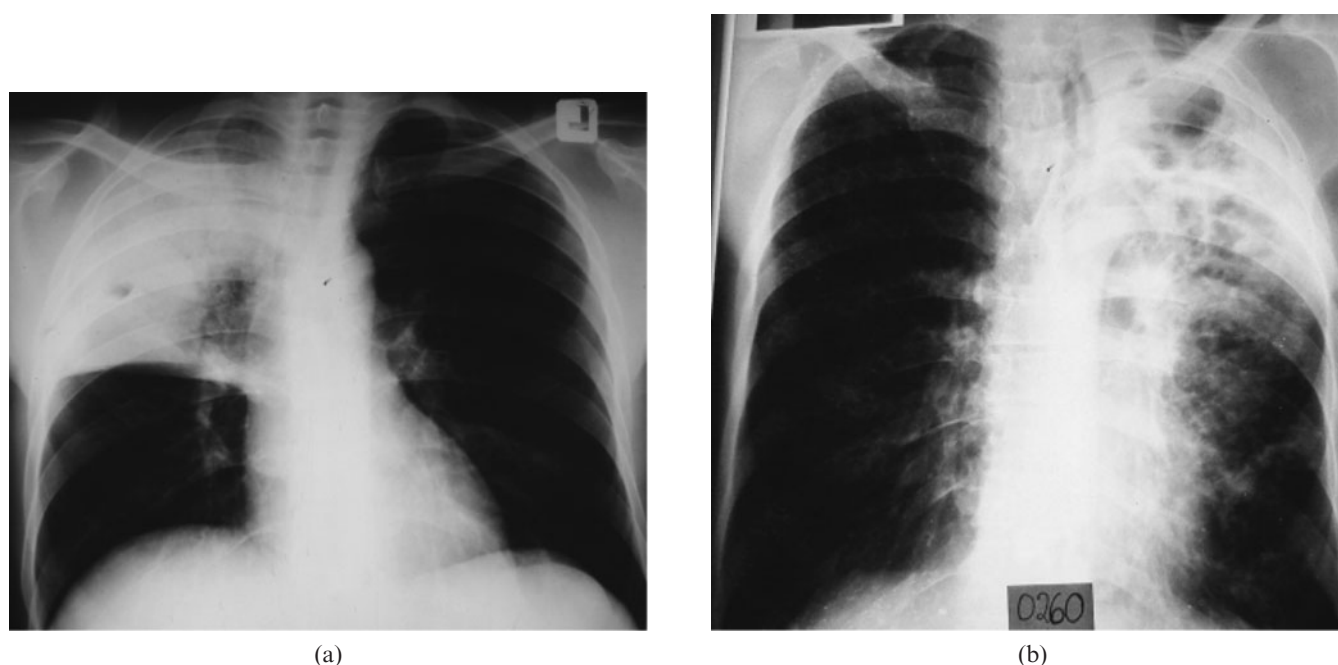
(a) Unilobar consolidation in an human immunodeficiency virus (HIV)-seropositive patient with bacterial pneumonia. A posteroanterior chest radiograph shows homogeneous opacity with air bronchograms involving the right upper and mid zones. (b) Fibrocavitating bronchopneumonia in an HIV-seronegative patient with tuberculosis. A posteroanterior chest radiograph shows homogeneous and ring opacities in the left upper and mid zones, reticulonodular infiltrates in the left lower zones and tracheal shift to the left.
